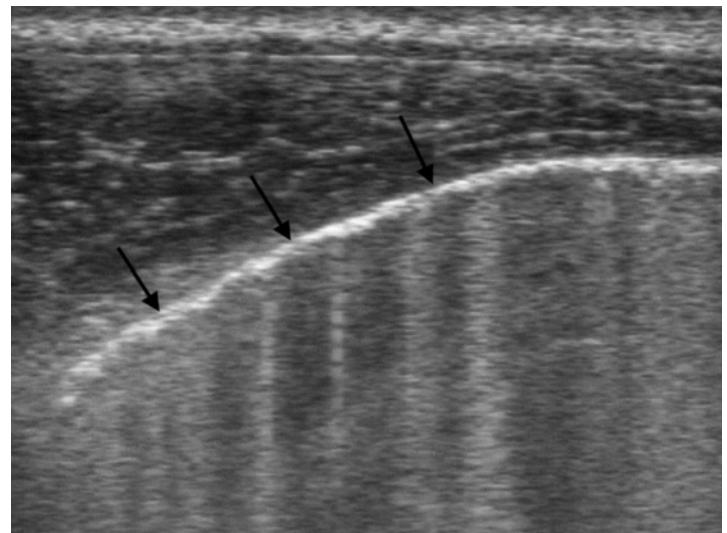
Ultrasound image of the pleura. Unobstructed visualization of the pleural border (black arrows) in the intercostal plane.
